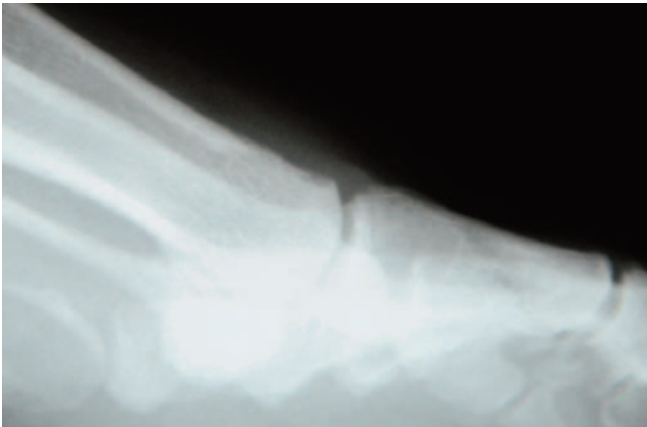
Case Study 2. Postoperative AP radiograph.
